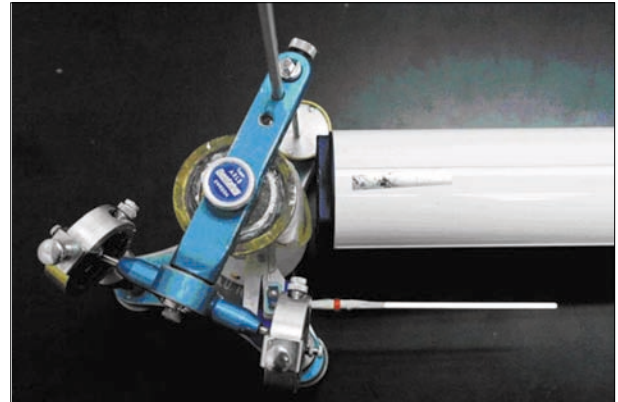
Positioning the cone for a radiograph.
